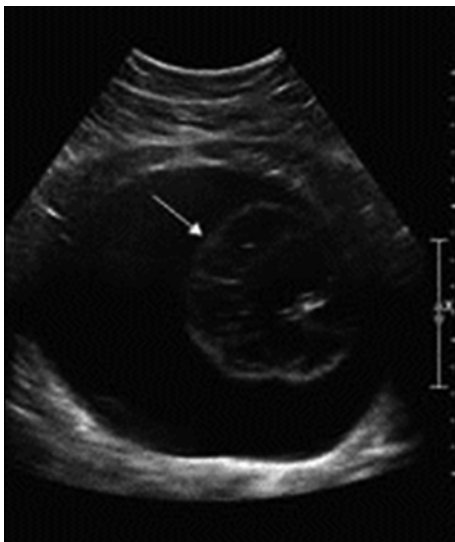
Ovarian teratoma. The ultrasound shows a 14 cm cystic mass and 7 cm solid component (*arrow*), referred to as a Rokitansky nodule (Reprinted from Kelleher and Goldstein [6], with permission)
